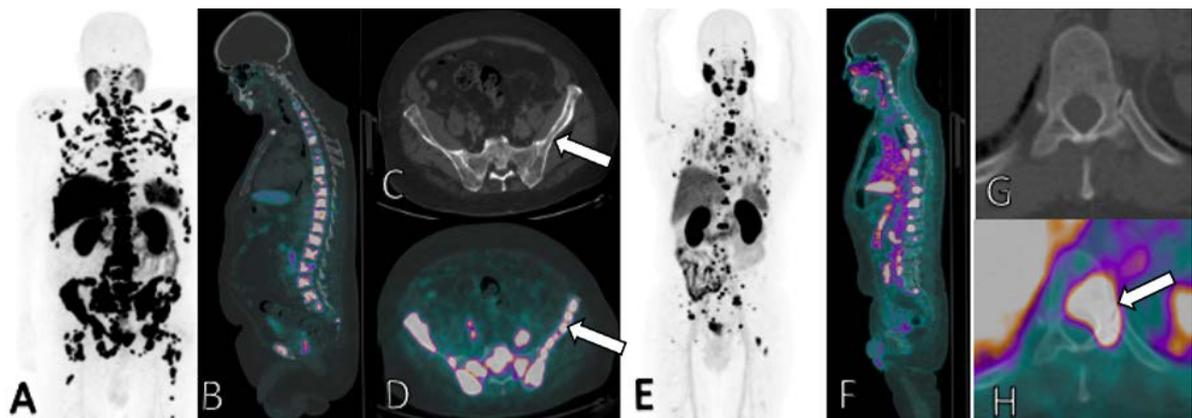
male patient with a 2-month history of lumbar pain and PSA of 233 ng/dl (A) MIP in anterior projection with uptake in the prostate and extensive lymph node and bone tumor burden. (B) PET/CT fusion in a sagittal section where we observe the spine with multiple lesions with intense radiopharmaceutical uptake. (C) and (D) CT and fusion in an axial section at the pelvis level with lytic lesions in both iliac and sacral intense uptake bones (white arrows). A 70-year-old male patient who attended staging for prostate cancer, at the time of the study had PSA of 110 ng/mg; (E) MIP in anterior projection with multiple lesions with intense uptake of diffuse distribution in the axial and appendicular skeleton. (F) PET/CT fusion with bone window in sagittal section; the spine is seen with multiple focal ^{18}F -PSMA uptakes. (G) CT and (H) fusion with PET shows intense radiopharmaceutical uptake involving body, peduncle, and left facet without anatomical representation (white arrow).
